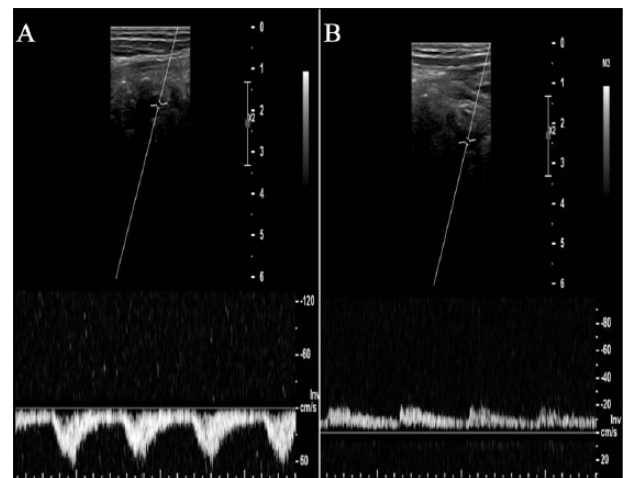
Echo-Doppler examination showing: (A) reversal flow in the right vertebral artery (B) recovery of normal flow after intervention.
